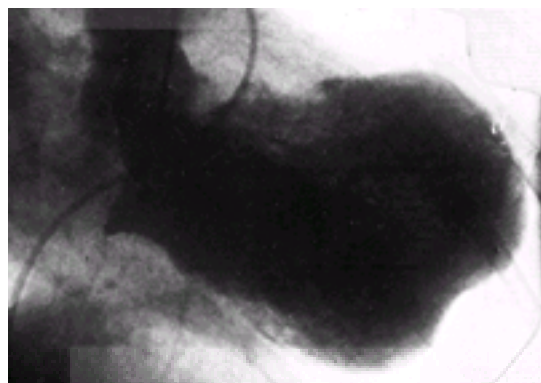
Left ventriculogram in a 30° right anterior oblique projection (end-systolic frame) showing a large anterior wall aneurysm. The patient was a 65-year-old man who had a massive myocardial infarction (peak creatine kinase measurement, 4,460 units) and showed subsequently a progressively enlarged cardiac silhouette on roentgenography. Catheterization 4 weeks after infarction demonstrated a large anterior wall left ventricular (LV) aneurysm, with LV pressure 95/40 mm Hg, pulmonary capillary wedge pressure 34 mm Hg, and occlusion of the left anterior descending artery proximal to the first septal perforator. Ejection fraction was 18%, and the other coronary arteries were normal.
